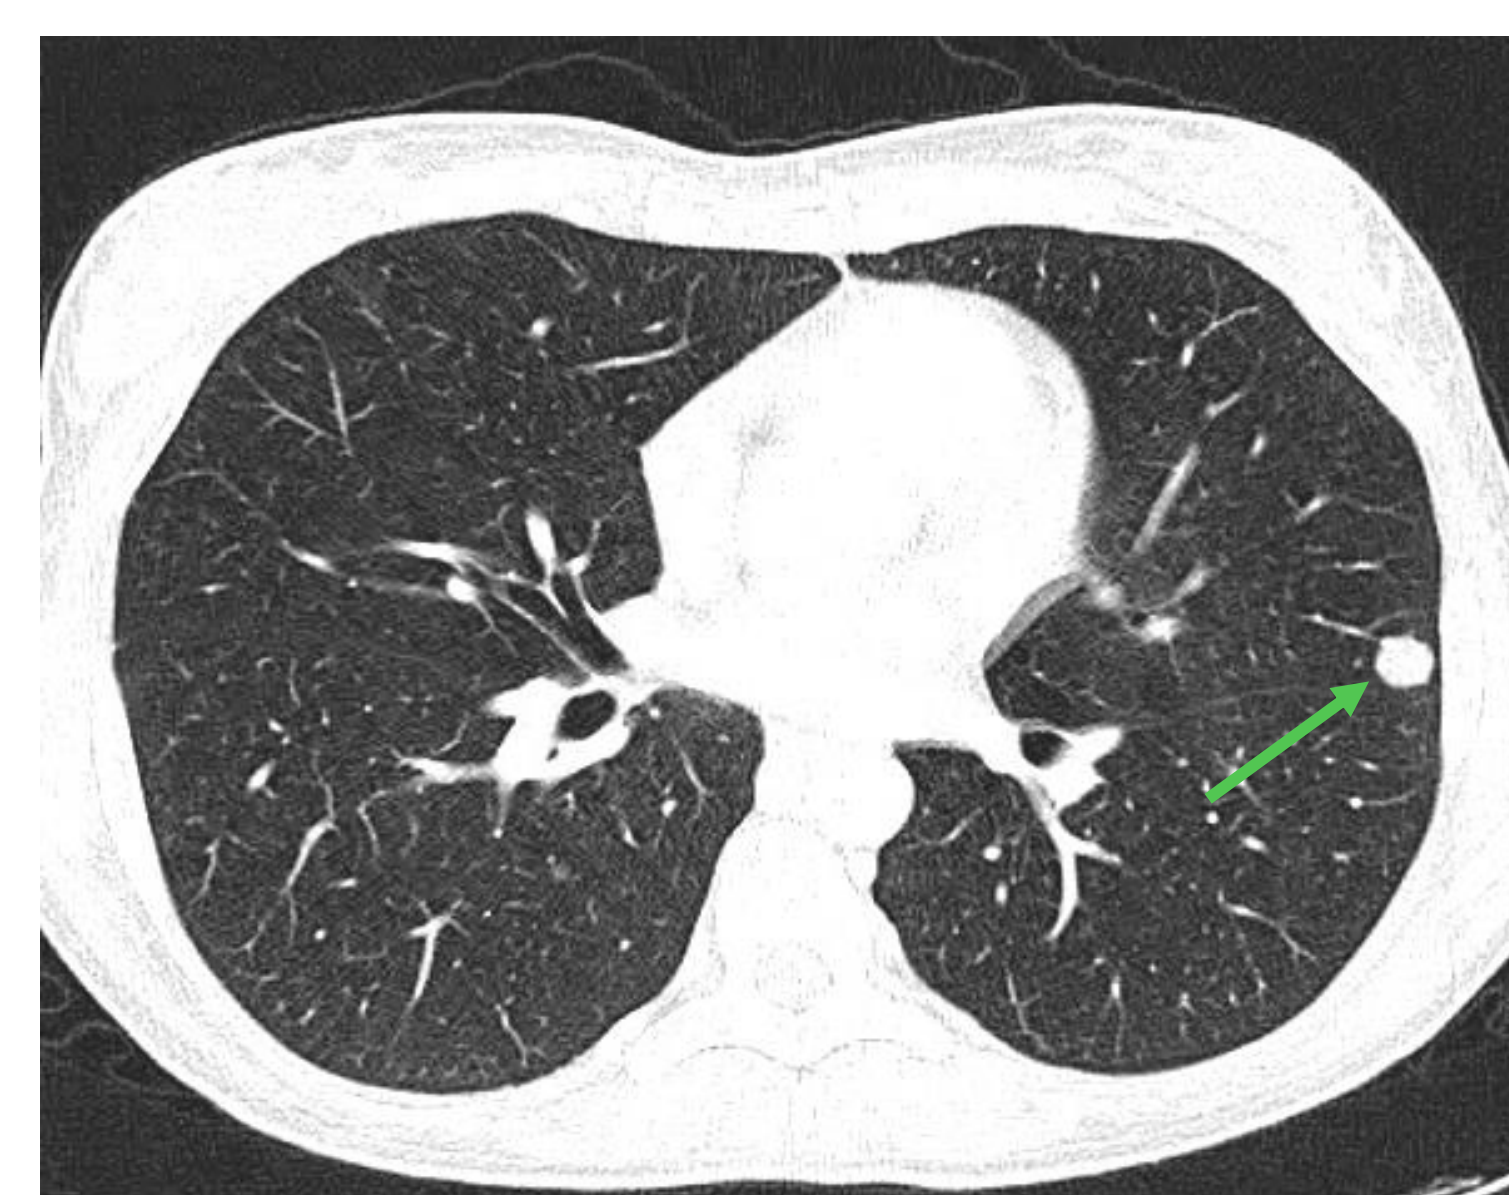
CT-scan showing pulmonary metastasis (green arrow).
